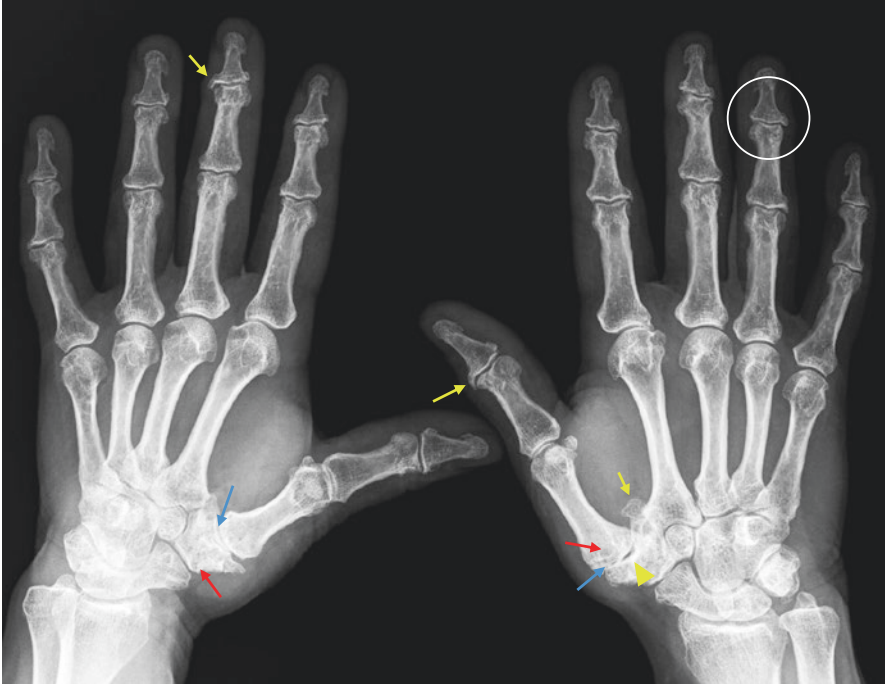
Radiographic findings in osteoarthritis – hands
